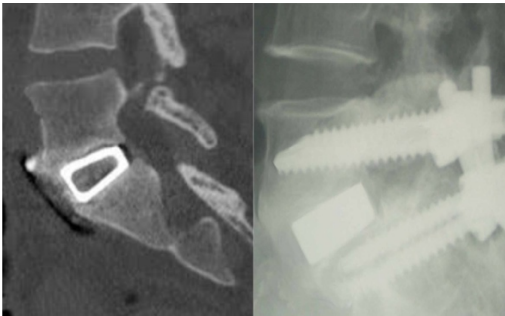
Radiological (CT scan and X-Rays) evidence of interbody fusion in ALIF (left) and TLIF (right) at the last follow-up. Brantigan Grade 5.
